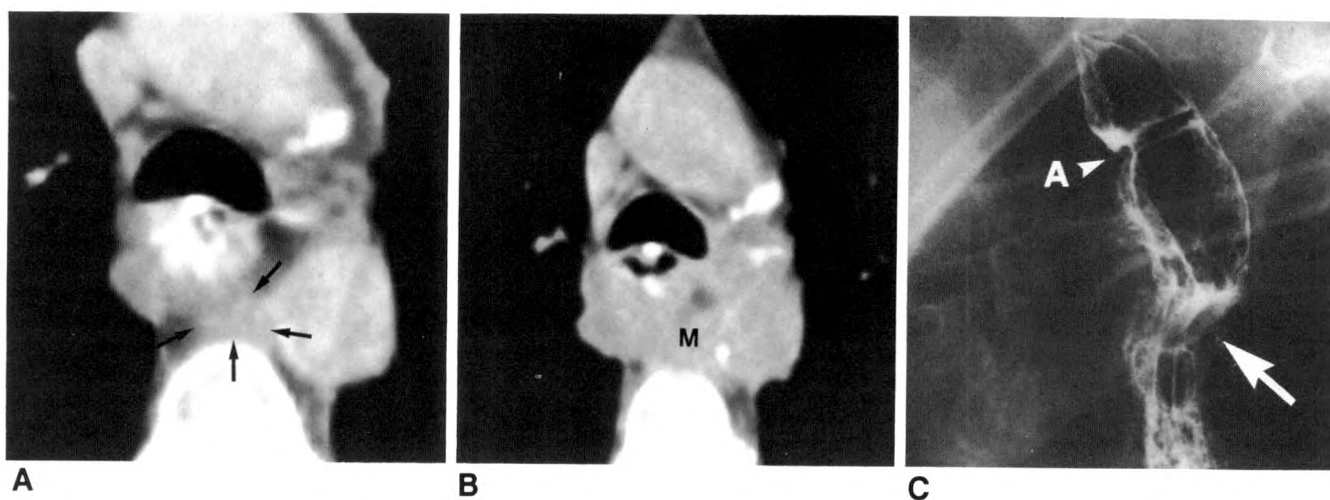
Local recurrence at primary site of esophageal carcinoma causing extrinsic impression of interposed stomach without mucosal infiltration. A, 3 months after transhiatal esophagectomy with gastric interposition for squamous-cell carcinoma of the upper thoracic esophagus, density of paraaortic fat is increased on CT (arrows). Because there are no other signs of inflammatory complications, recurrent carcinoma must be suspected.
